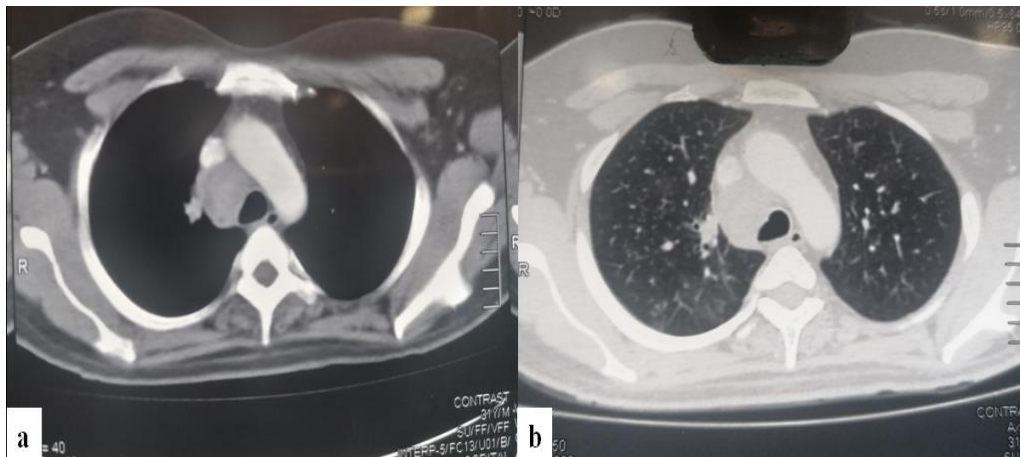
Contrast-Enhanced Computed Tomography (CECT) of the chest when starting Anti-Tubercular Therapy (ATT). a) The mediastinal window shows an enlarged right paratracheal lymph node; b) the lung window shows bilateral upper lobe nodular opacities.
